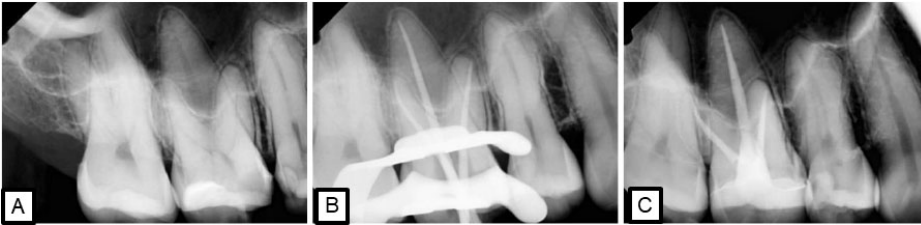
(A) pre-operative radiograph, (B) masterpoint gutta-percha trial, (C) post-operative overlay restoration radiograph.
